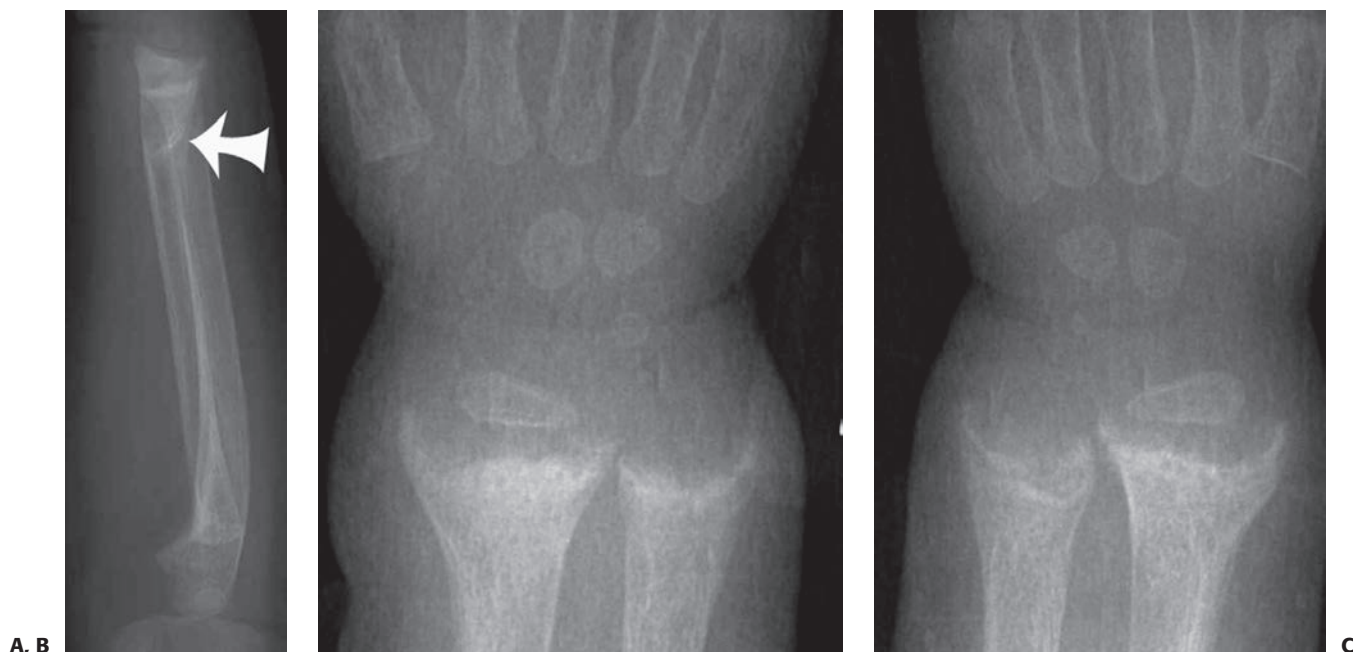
Rickets in a 16-month-old male who was breast-fed. A: Lateral forearm radiograph shows osteopenia and a distal radial fracture (*arrow*) with some dorsal angulation (B, C). Metaphyseal cupping and fraying of the distal radius and ulna bilaterally are also noted.
